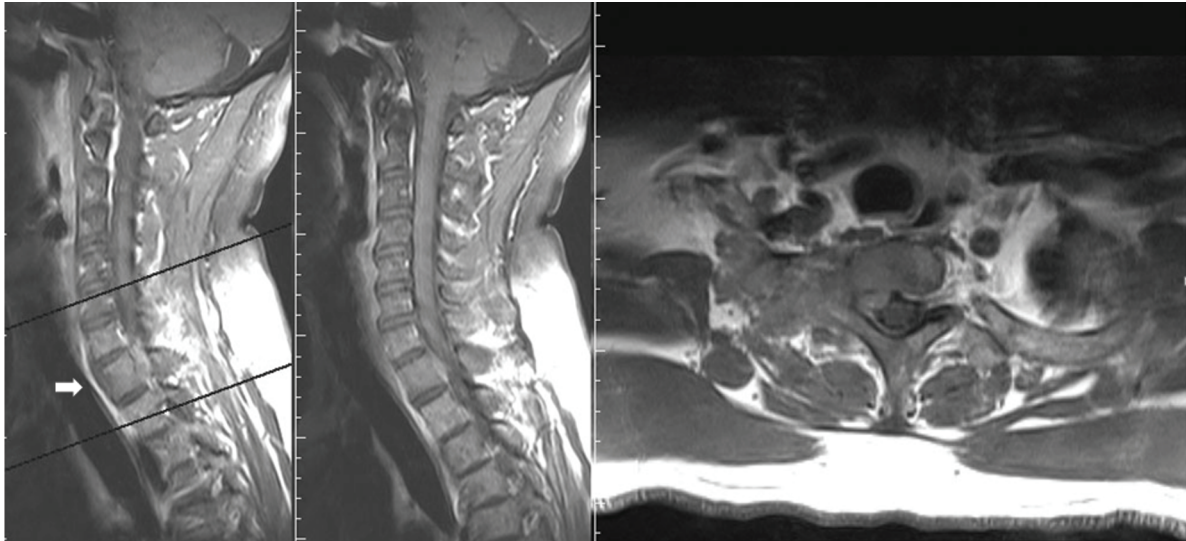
MRI of the cervical spine revealed numerous small, similar-appearing hypodense lesions distributed throughout the cervical and thoracic bodies. Tumor impingement upon the right T1/2 foramen is seen (arrow)
